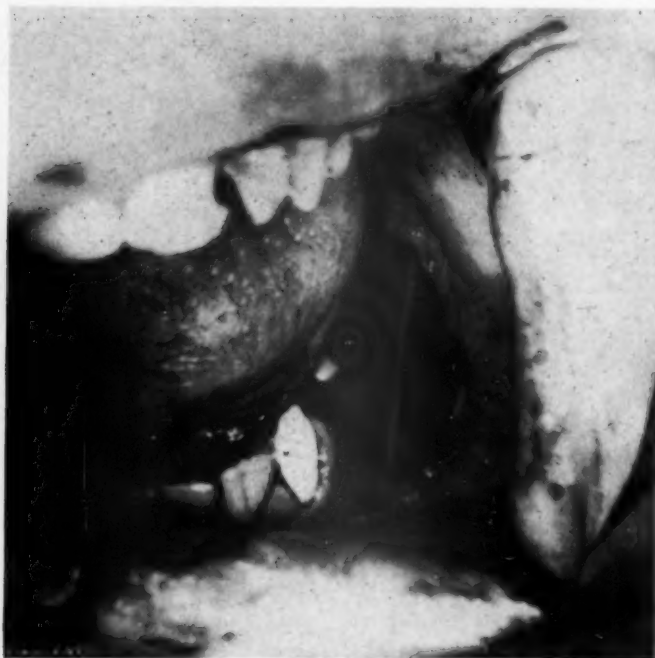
X-ray of mandibular cyst, anteroposterior view.
